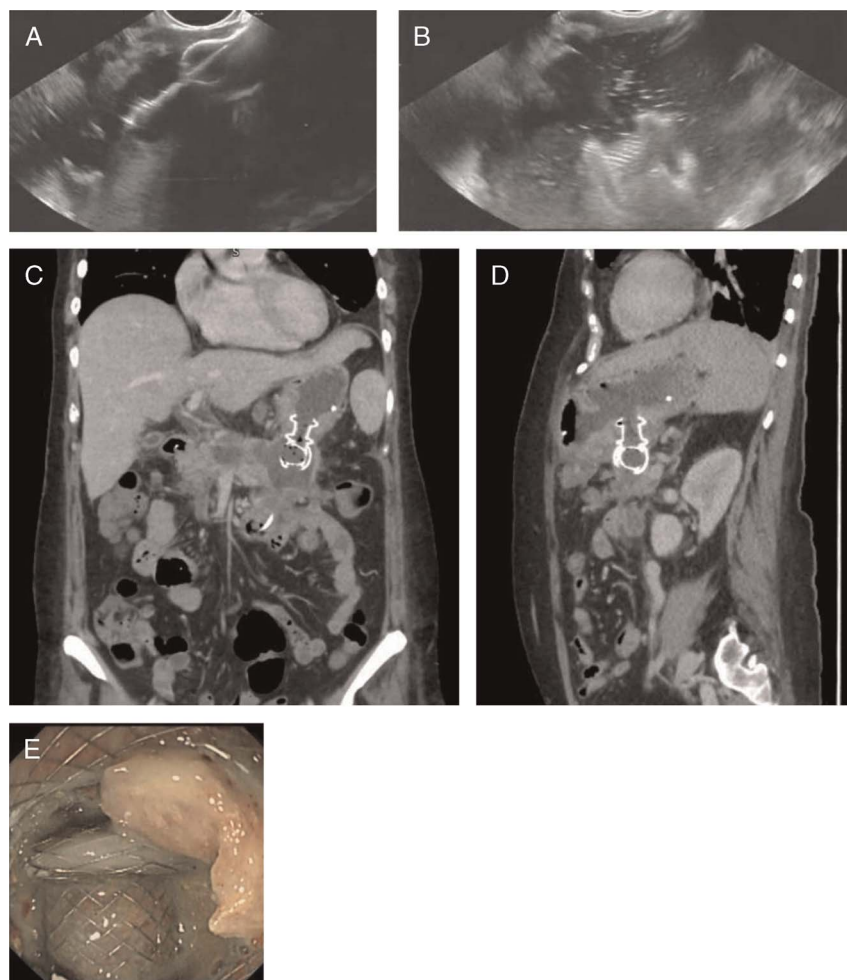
A, EUS-guided deployment of a 15-mm-diameter LAMS. B, EUS views of the stent misplaced in the peripancreatic fluid collection. C and D, Coronal and axial CT scans showing the stent misplaced within the pancreatic walled-off necrosis and the second correctly placed transgastric Hot AXIOS stent. E, After 3 weeks and improvement in clinical situation, the misplaced stent could be retrieved endoscopically using a biopsy forceps through the correctly placed also 15-mm-diameter stent, leaving the correctly placed stent for 4 more weeks until near-complete resolution of the collection. CT: computed tomography; LAMS: lumen-apposing metal stents.
